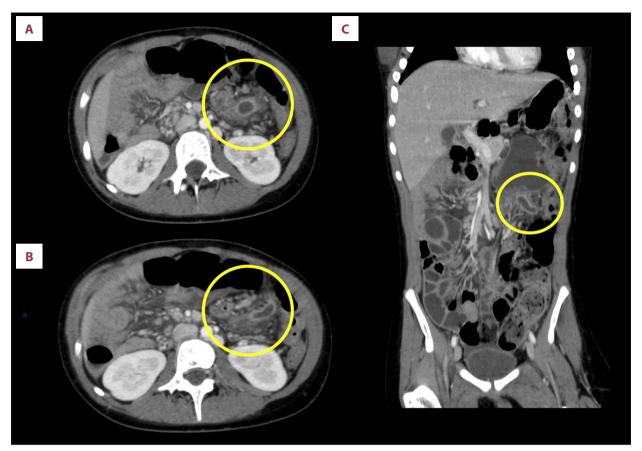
Axial (A, B) and coronal (C) Images of an IV contrast-enhanced abdominopelvic CT demonstrates a left upper-quadrant fluid-filled dilated appendix, with hyper-enhancing walls, surrounding inflammatory fat stranding, and multiple pericecal mesenteric lymph nodes.
